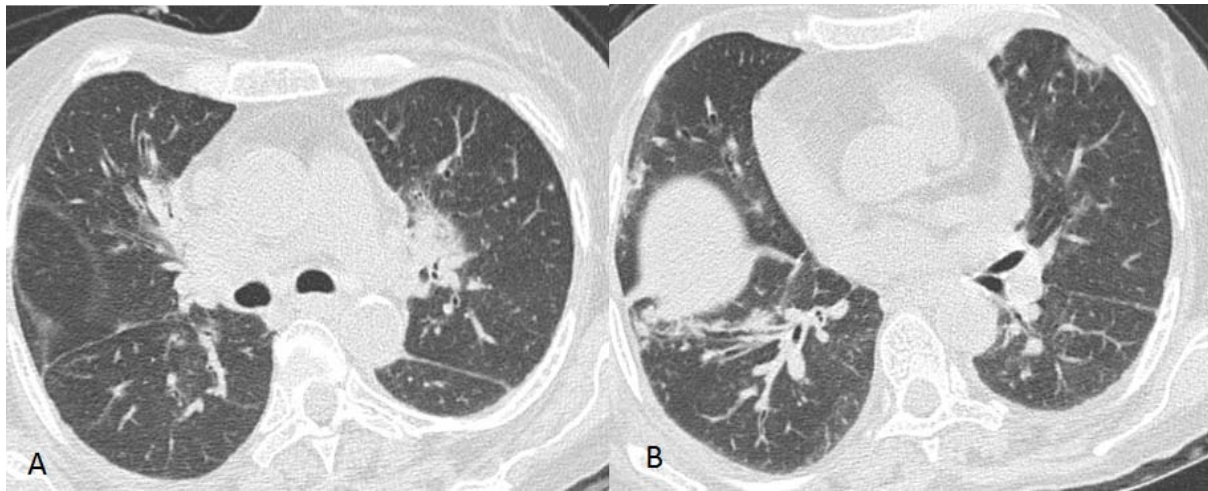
HRCT of thorax showing patchy areas of alveolar consolidation in the right middle lobe, in lingula (A) and multiple small nodular lesions in the peribronchial region in the anterior basal segment of the right lower lobe (B)
